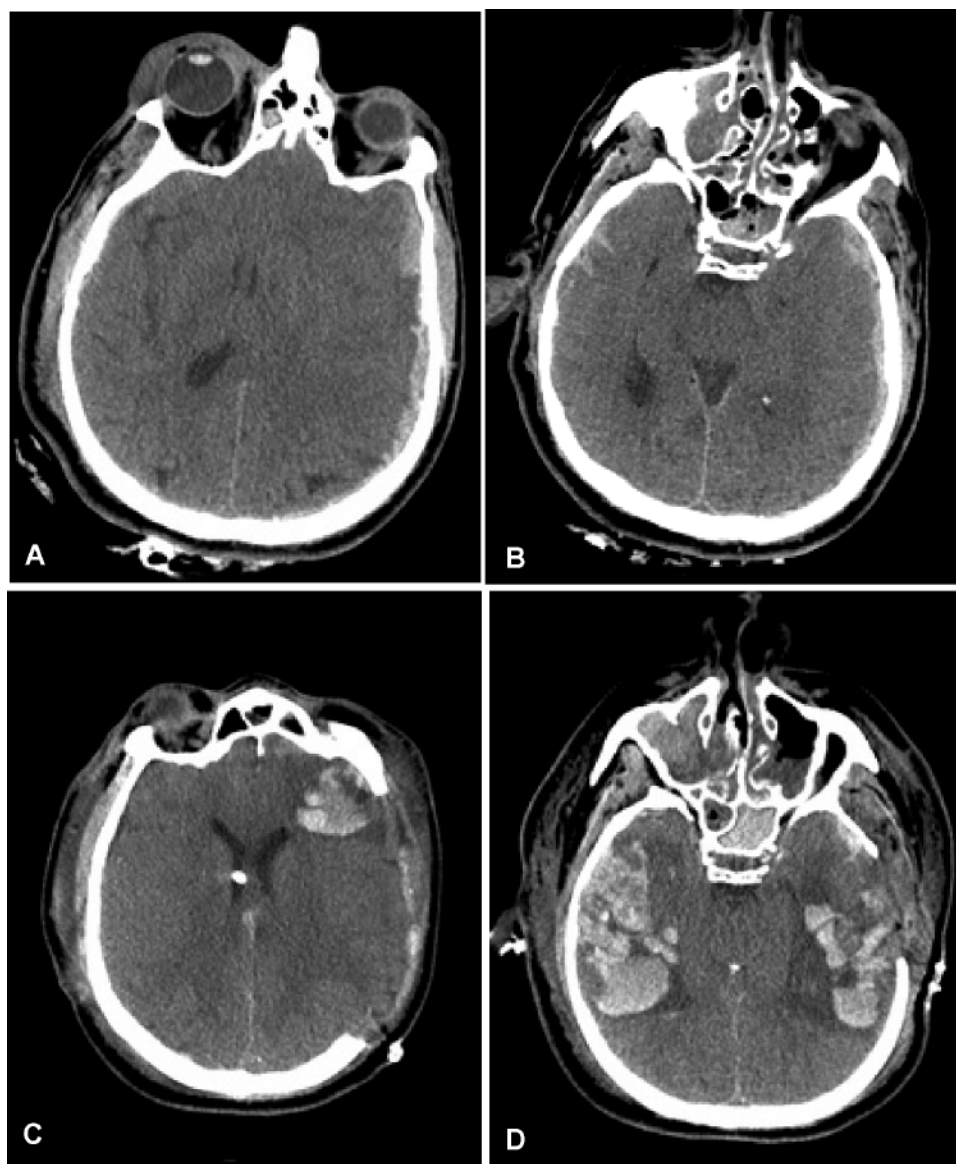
Contusion blossoming. Preoperative (A and B) and postoperative (C and D) noncontrast CT images demonstrating massive temporal contusions following decompressive craniectomy. Note the relative absence of parenchymal lesion burden in the temporal lobes on the preoperative images.
